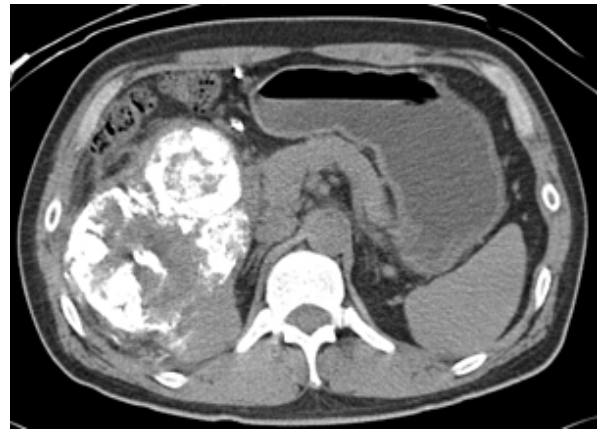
One month follow-up CT scan shows nodular compact lipiodol uptake in embolized area fed by a branch of splenic artery. Note the lipiodol retention in aberrant branch of splenic artery.
